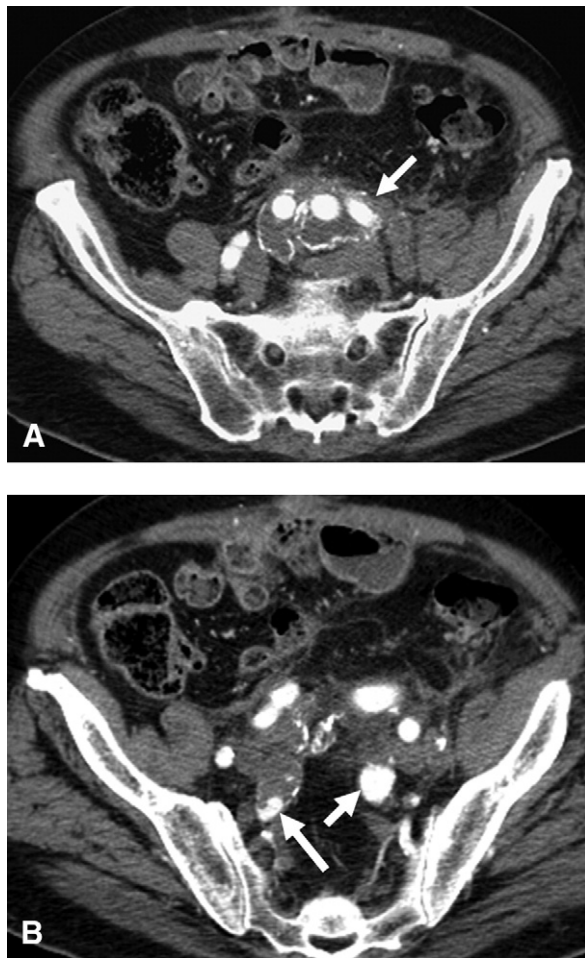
A postoperative computed tomography scan at 1 month shows (A) patent left hypogastric artery bypass graft (*arrow*) and (B) patent left distal hypogastric artery (*short arrow*) with cross filling of the right (*long arrow*).
